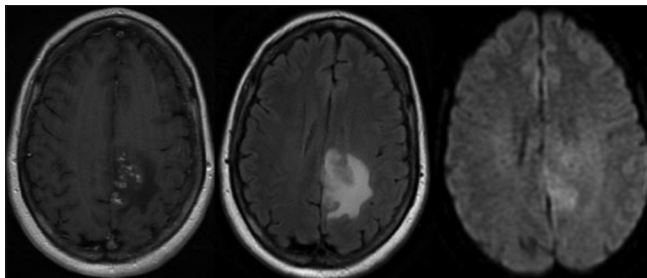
T1 with contrast, FLAIR, and DWI MRI shortly after presentation
